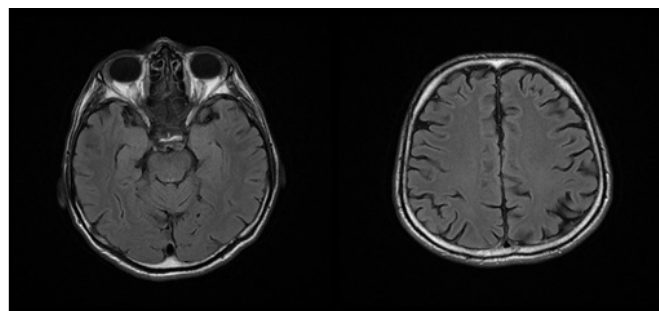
The lesions are observed to regress on a control FLAIR sequences axial MRI.
